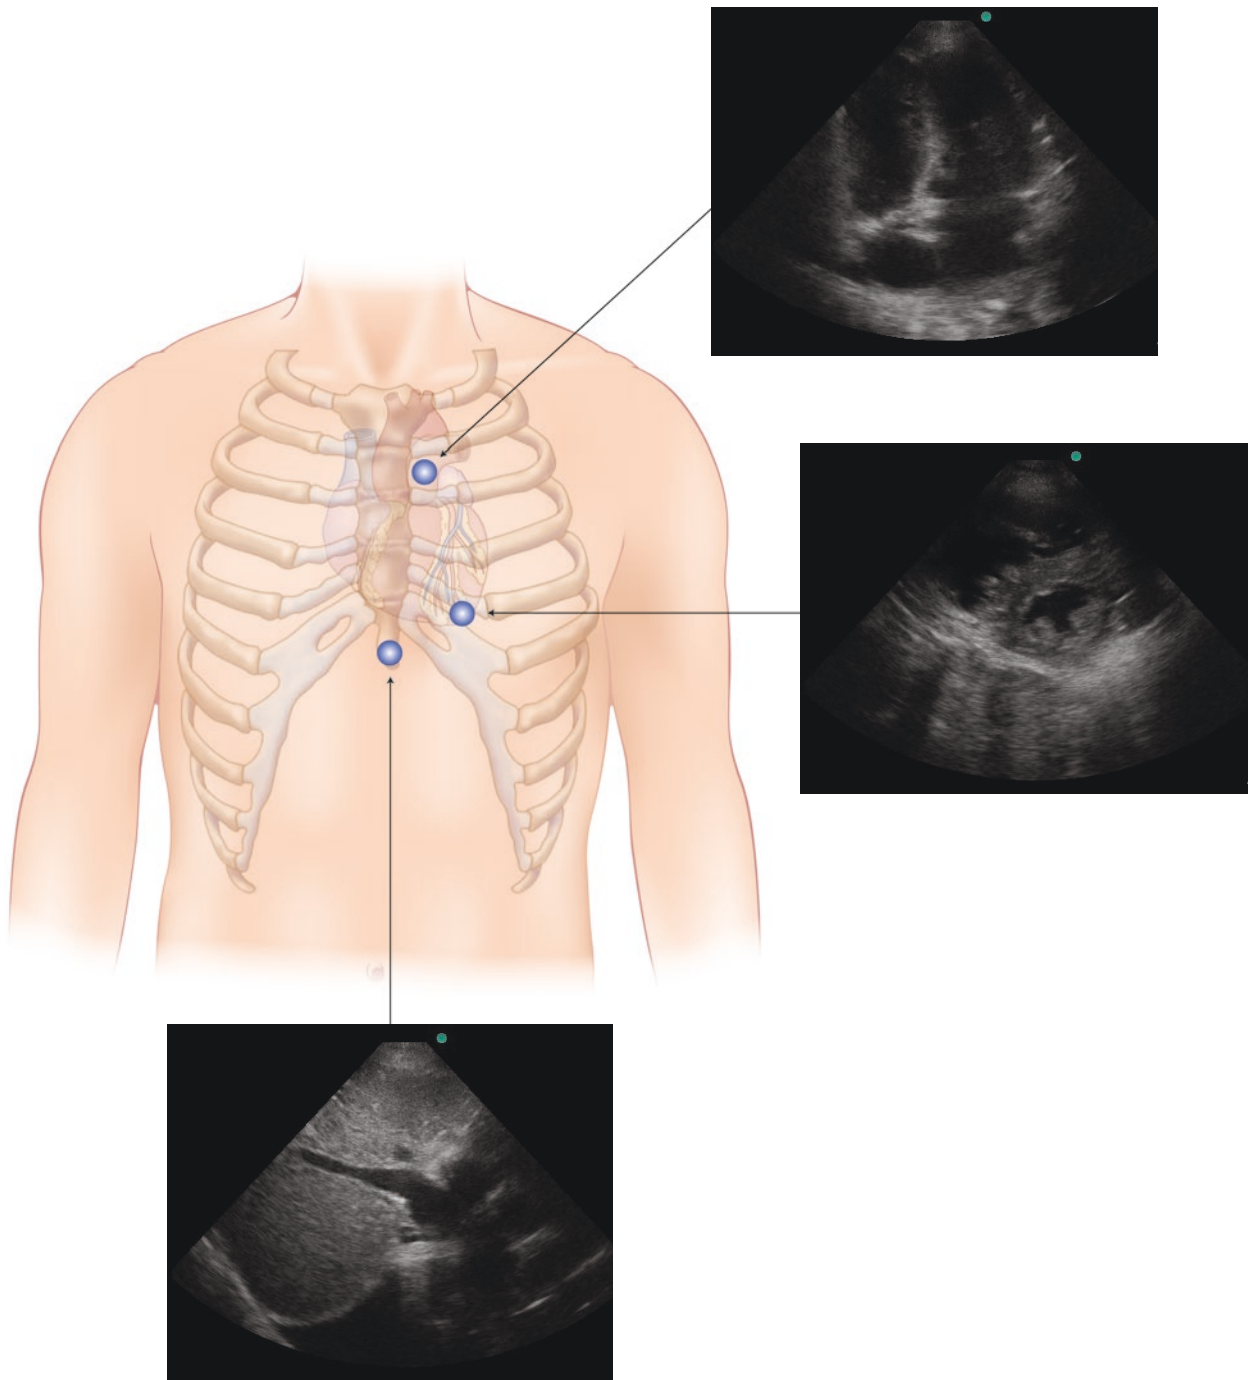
Transthoracic echocardiography probe positions and corresponding views
